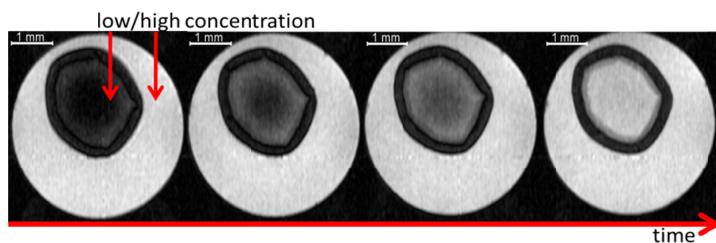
MR images of a contrast agent diffusing into a microcapsule leading to time dependent signal amplitudes within the capsule core.
